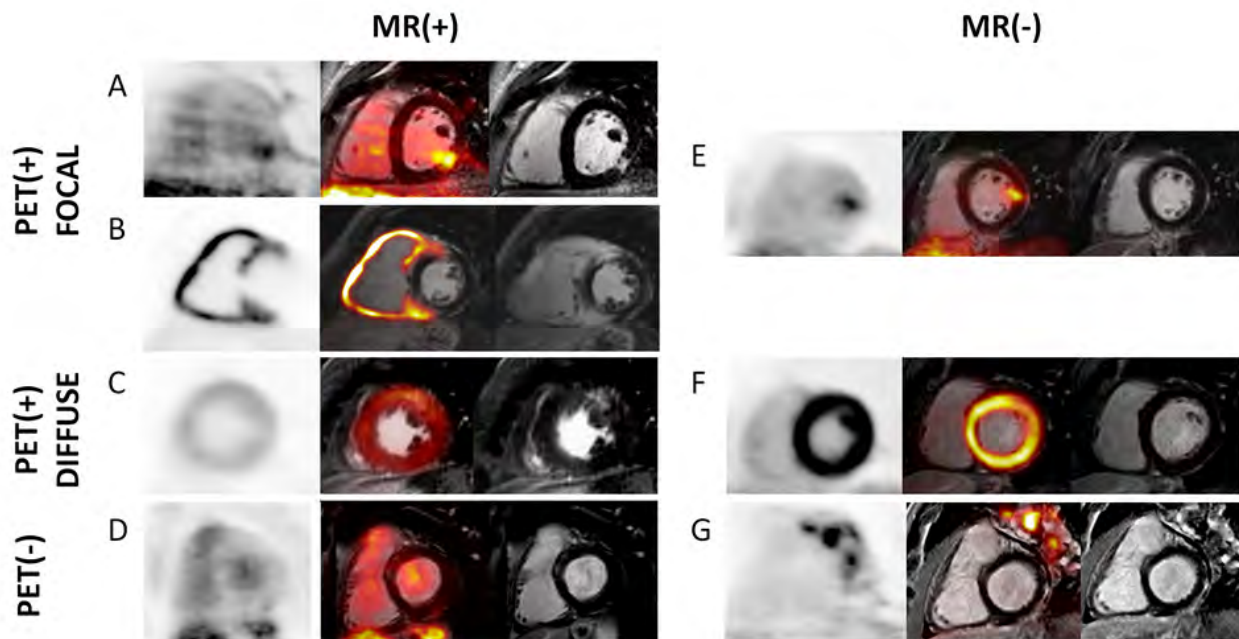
Representative short axis 18F-FDG PET (left), LGE MR (right) and fused MR/PET (middle) images for each of the six image-based categories. A: MR(+)<sub>PET(+)</sub><sub>FOCAL</sub> , B: MR(+)<sub>PET(+)</sub><sub>FOCAL</sub> with predominantly right ventricular involvement that was subsequently confirmed by cardiac biopsy, C: MR(+)<sub>PET(+)</sub><sub>DIFFUSE</sub> , D: MR(+)<sub>PET(-)</sub> , E: MR(-)<sub>PET(+)</sub><sub>FOCAL</sub> , F: MR(-)<sub>PET(+)</sub><sub>DIFFUSE</sub> , G: MR(-)<sub>PET(-)</sub> with extra-cardiac 18F-FDG uptake.
